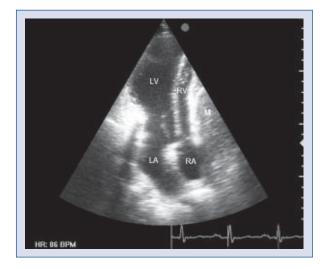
Apical four-chamber window of transthoracic echocardiography showing a mass (M) compressing the right ventricle (RV); RA — right atrium; LA — left atrium; LV — left ventricle.
